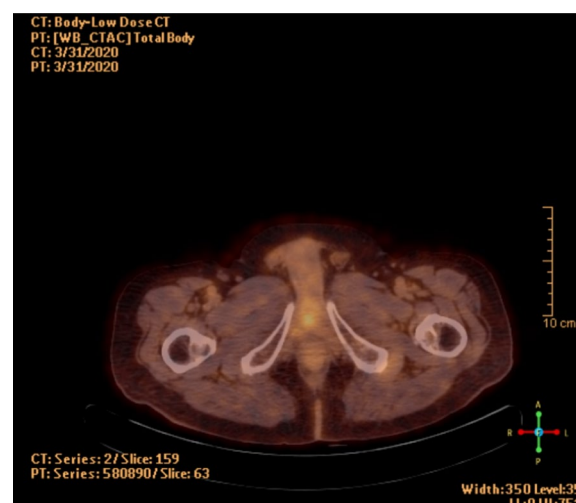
Postoperative first month, increased pathological F-18 FDG uptake in the periphery of the mass in the penile urethra and indistinguishable boundaries from the prostatic urethra
